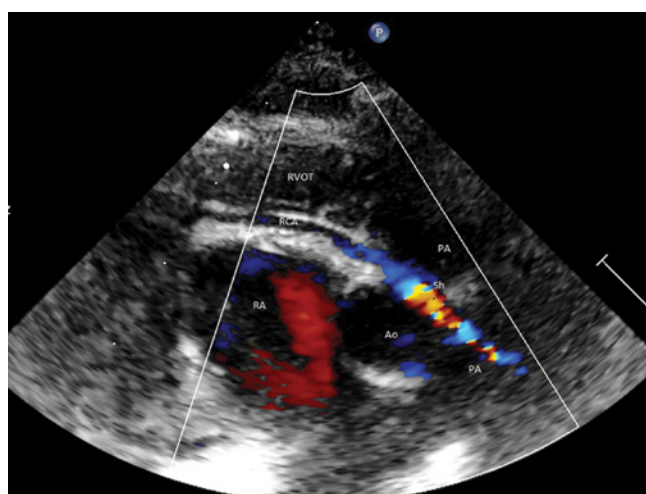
Preoperative ECHO. Modified cross-sectional parasternal vascular projection. See the inflow from the right coronary artery to the pulmonary artery. Ao – cross-section of the ascending aorta, PA – pulmonary artery trunk, RCA – right coronary artery, RVOT – right ventricular outflow tract, RA – right atrium, Sh – RCA-PA shunt.
